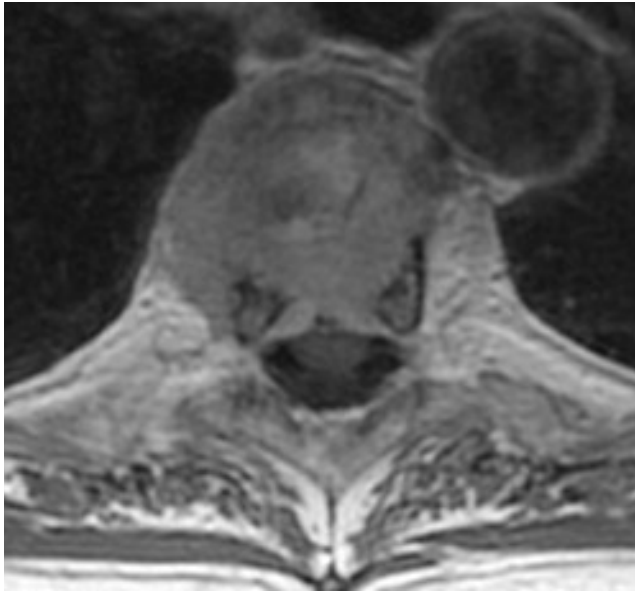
MRI (T2) of the thoracic spine without contrast: metastasis of an adenoid cystic carcinoma. Tumor extension into the anterior part of the epidural space, well seen on sagittal view on T2-weighted sequences. Para-sagittal views show loosening of the posterior longitudinal ligament.
